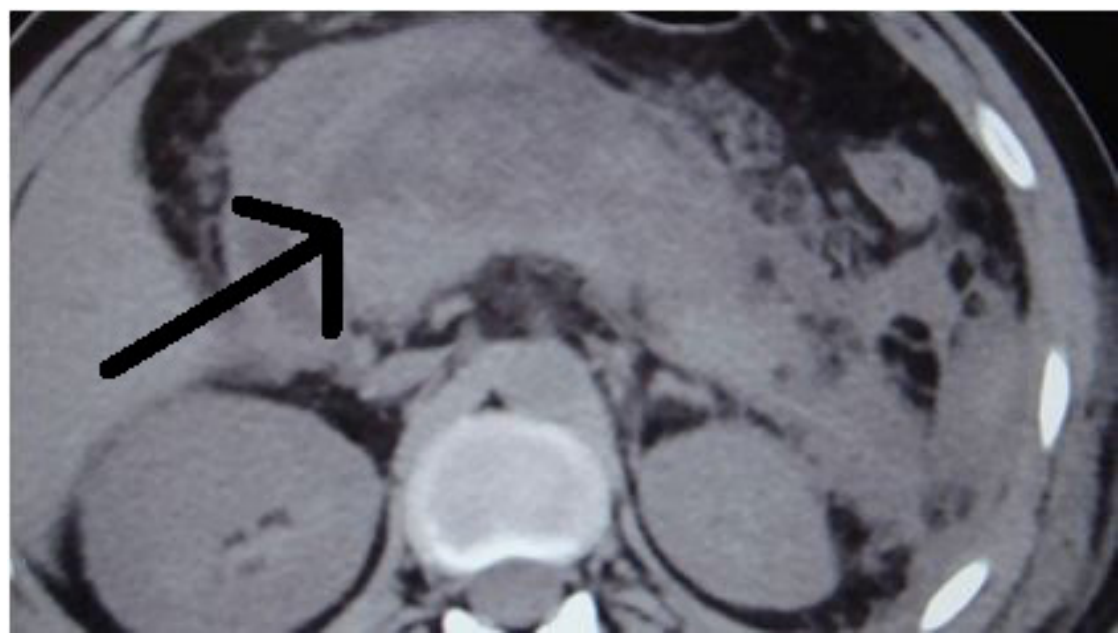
Contrast enhanced CT scan of abdomen of the patient showing edematous pancreas (black arrow) with peripancreatic edema.
